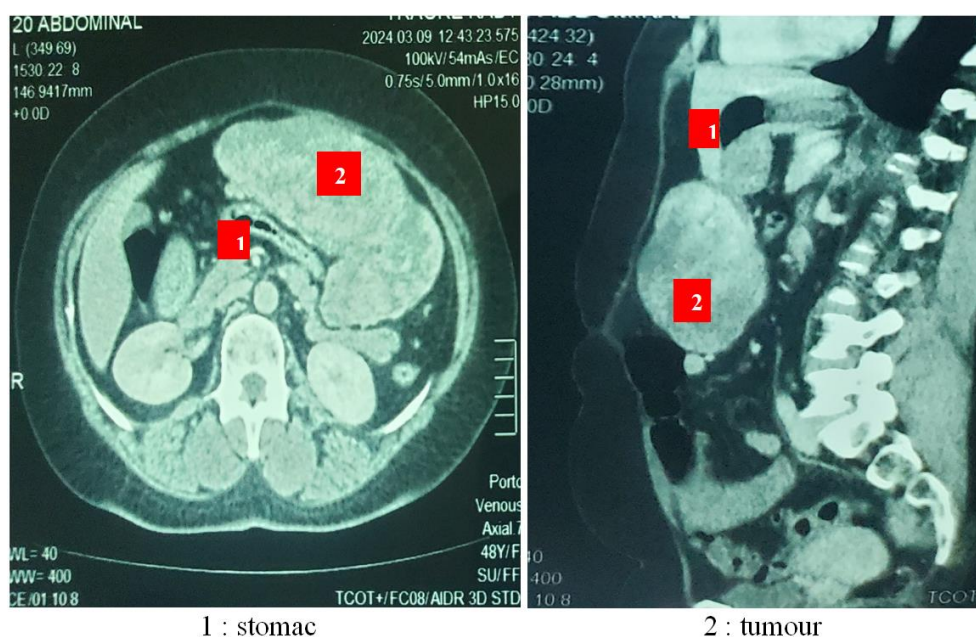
Transverse and sagittal CT scans showing a tumour developing at the expense of the gastric wall.
